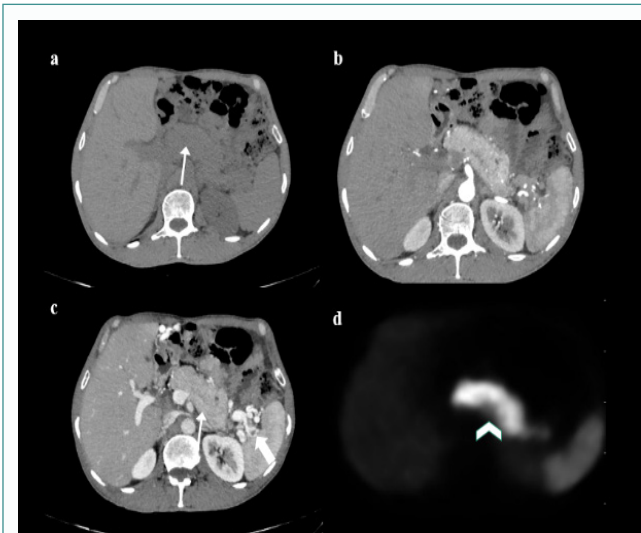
Panel a depicts a plain section computed tomography scan showing unenhanced pancreas (arrow). Panel b depicts the pancreatic parenchymal (arterial) phase showing a bulky pancreas with uniform enhancement. In panel c, portal venous phase, there is slight reduction in enhancement compared to the arterial phase. The thin arrow points to the thrombosed splenic vein. The thick arrow points to perisplenic collaterals. Panel d depicts a section of DOTANOC positron emission tomography scan in which the body and tail of pancreas show diffuse uptake (arrow head).
